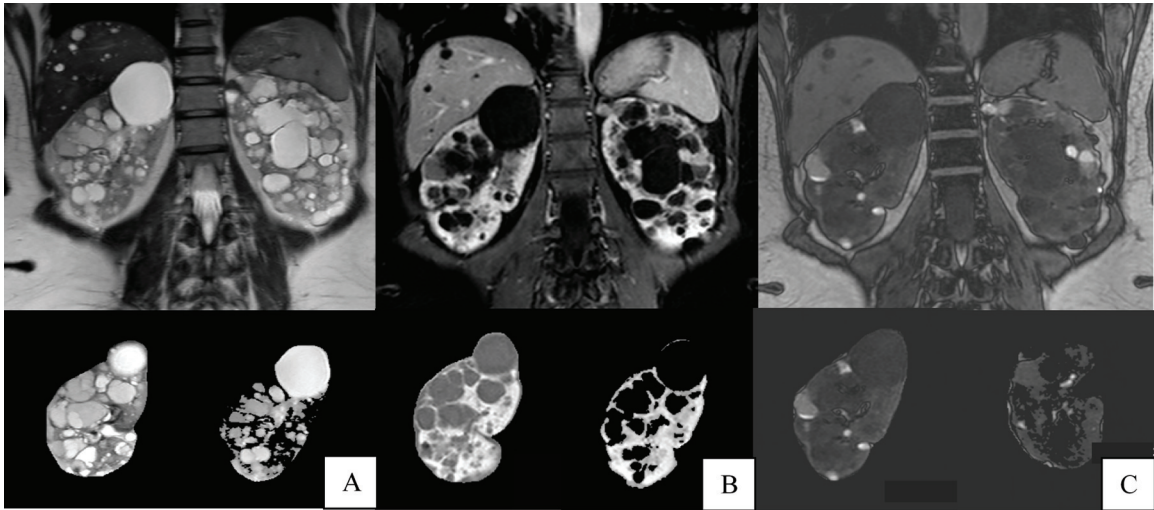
Total kidney volume (TKV) and cyst volume measurement on coronal sstT2-weighted images of the right kidney of a 46-year-old woman with autosomal dominant polycystic kidney disease (A). TKV and parenchymal volume of the right kidney on THRIVE T1W post-gadolinium contrast enhanced MRI (3rd phase) (B) and on IDEAL (opposed phase) (C) using manual segmentation and a thresholded volumetric measurement method.
